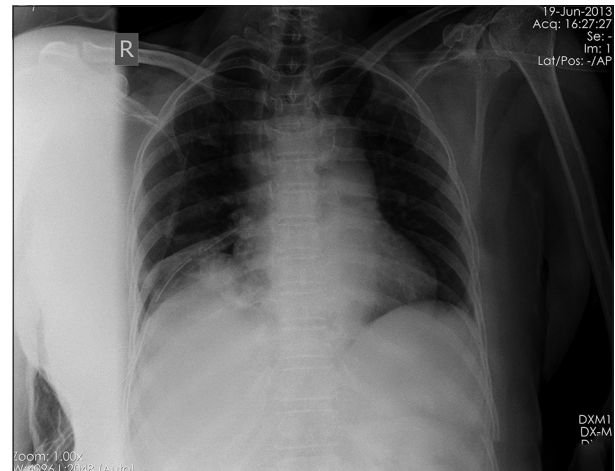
X-ray of the chest after ICD insertion
